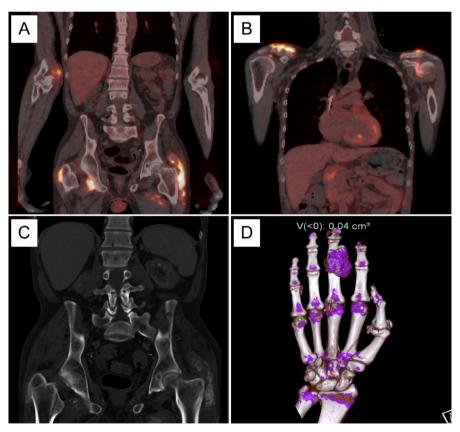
Periarticular calcification on computed tomography images. (A) PET-CT image showing uptake of 18F-fluorodeoxyglucose consistent with inflammation in the calcified periarticular tissue around hip joints and around right elbow joint. (B) PET-CT image showing uptake of 18F-fluorodeoxyglucose in the calcified periarticular tissue in the shoulders. (C) Computed tomography image showing massive periarticular calcification in the area of left hip joint. (D) Dual energy computed tomography image showing no findings consistent with monosodium urate deposits in the right hand.
